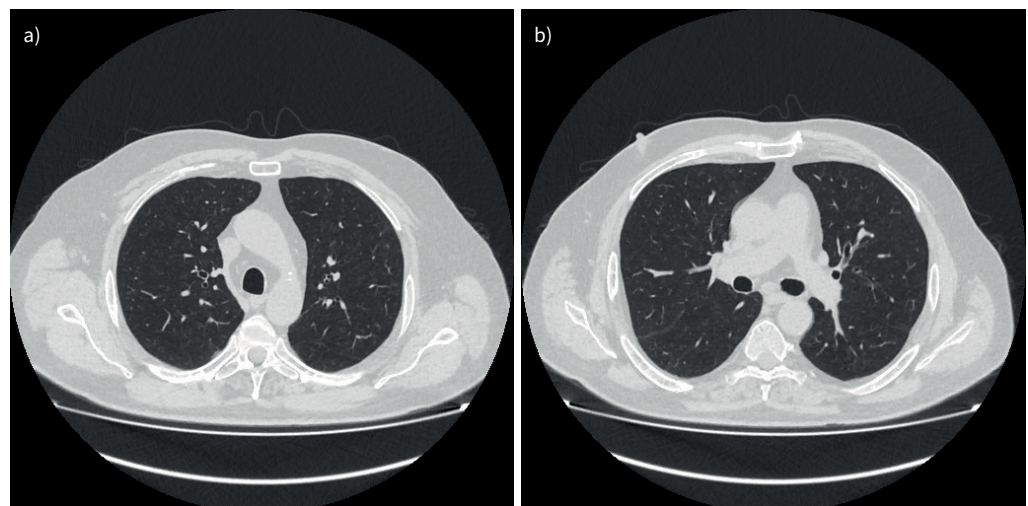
a, b) Follow-up chest computed tomography 3 months after the images shown in figure 3 (3 months after mesalazine discontinuation): complete resolution of bilateral ground-glass opacities, small centrilobular nodules and mosaic attenuation.
